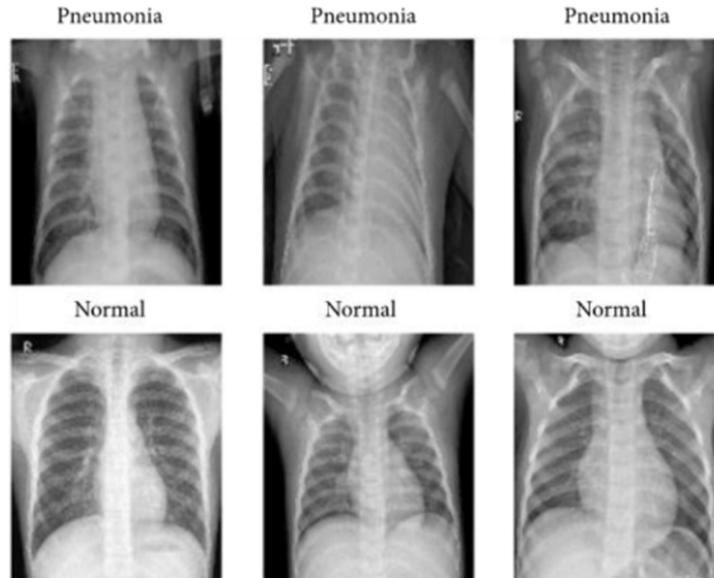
Normal and Pneumonia chest x-ray
